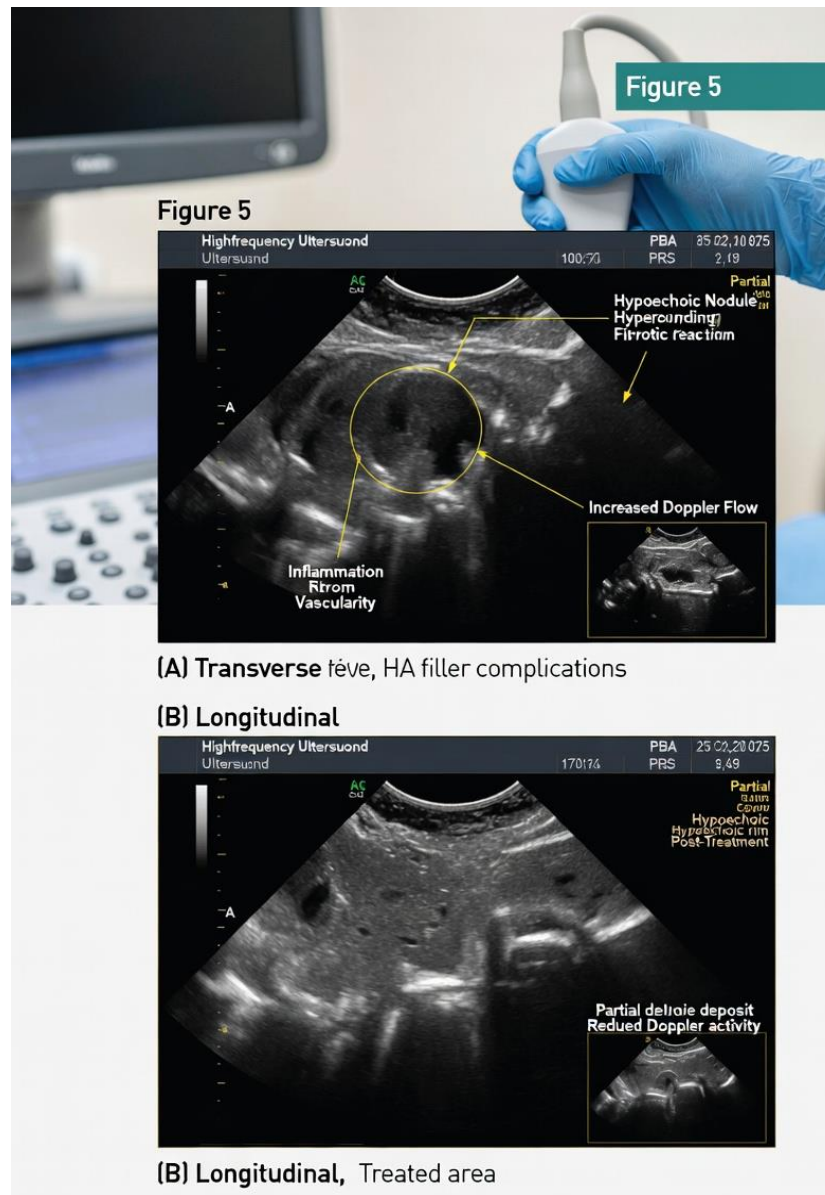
High-Frequency Ultrasound Images of HA Filler Complications
